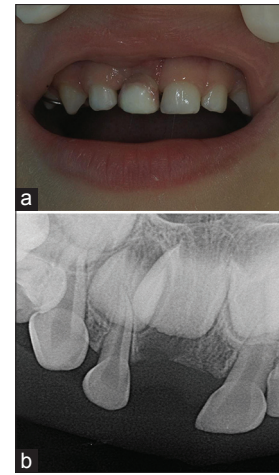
Intraoral view and periapical radiograph of the patient (3 months after surgery)
